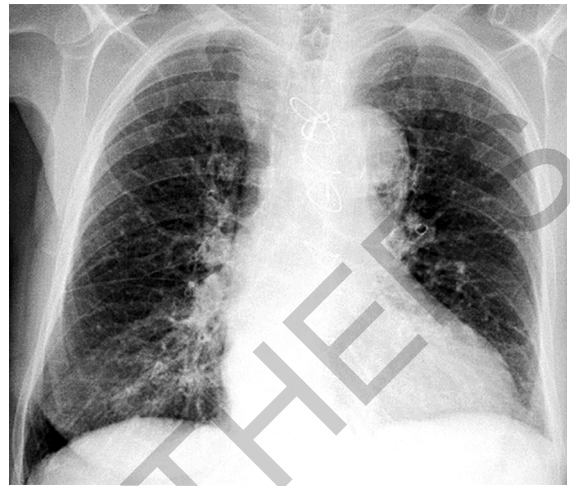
Chest X-ray—translucent, depressed, or flattened diaphragm, spike-like projections on bronchogram, enlarged heart, pulmonary vascular engorgement, and increased anteroposterior chest diameter (barrel chest).
